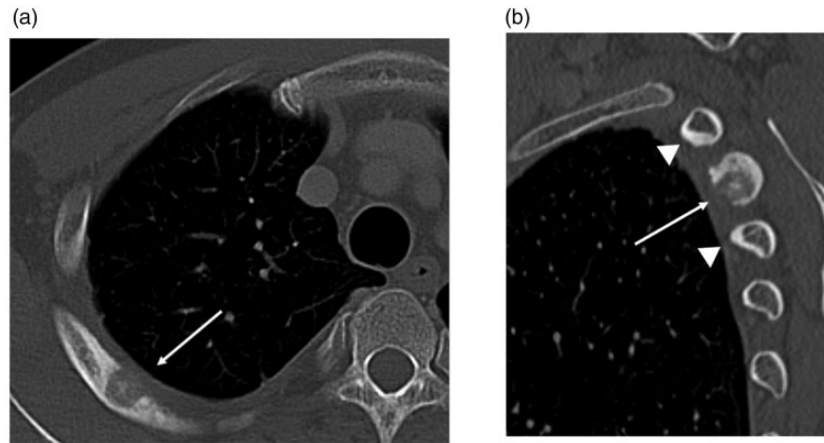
Noncontrast-enhanced CT scans. (a) Noncontrast-enhanced CT scan (Bone condition, window level (WL) = 500 Hounsfield Unit (HU), window width (WW) = 2500 HU), axial image. (b) Noncontrast-enhanced CT scan (Bone condition, WL=500 HU, WW=2500 HU), sagittal image. CT scan showed a 10-mm-sized circular bone translucent image is observed on the right fourth rib, with small calcification inside (a, arrow). The lesion contained an intracortical calcified nidus and was surrounded by sclerosis. A sclerotic change is observed in the surrounding bone (b, arrowhead), and an increase in the surrounding soft tissue concentration and the pleural thickening are observed.
